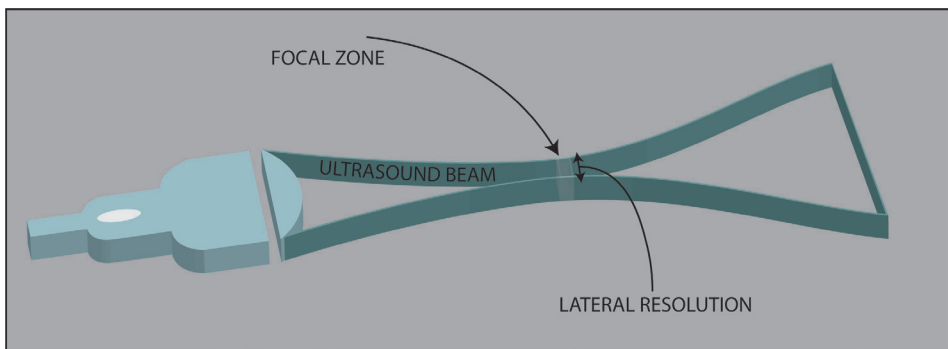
ultrasound beam, focal zone and lateral resolution.
